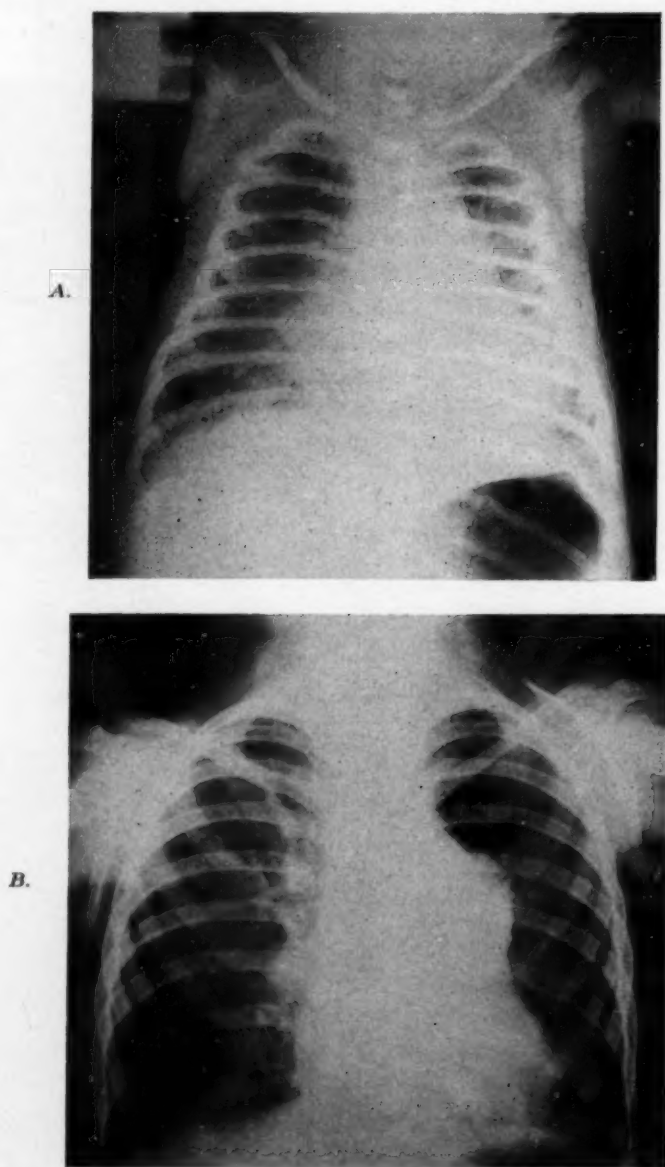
X-rays of the chest of L.J. A, Taken when 6 days old. Note the heavy vascular markings and very large heart. B, Taken when 3½ years old. Note the decrease in heart size, clarity of the lung fields, and huge main pulmonary artery.
